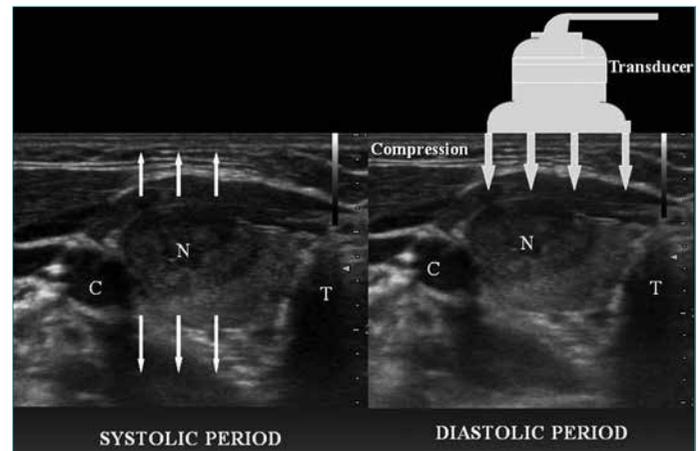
B-mode sonographic images show the systolic (left image) and diastolic periods (right image) of the main carotid artery. Left: No compression was applied in the systolic period. Right: Manual external compression was applied in the diastolic period
